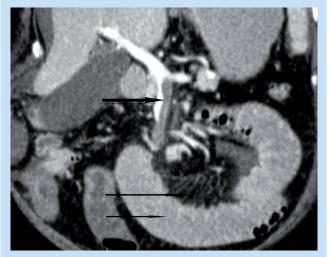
The porto-venous phase of a contrast-enhanced reconstructed coronal CT study. The SMV thrombosis is extending up to the confluence with the splenic vein. The top arrow indicates the thrombosis. Note the mesenteric congestion (middle arrow) and the dilated bowel (bottom arrow).
